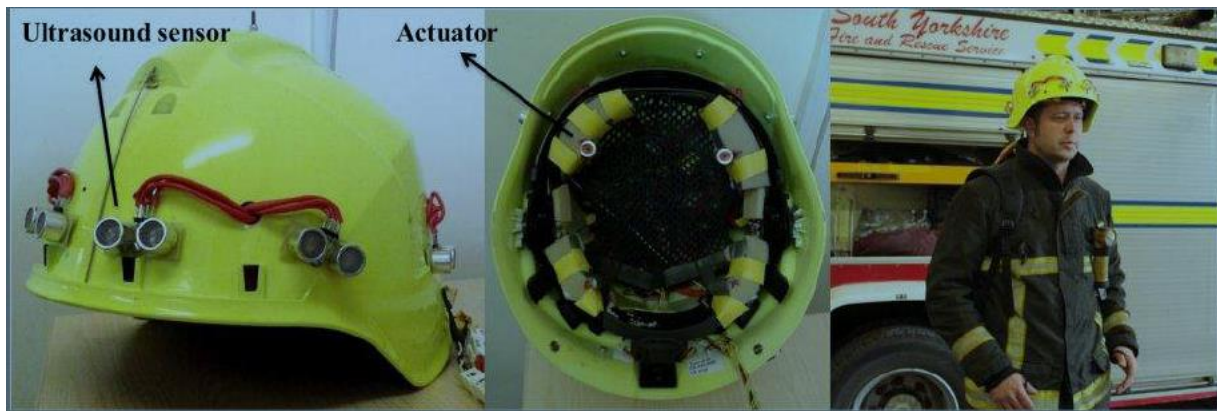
Vibrotactile firefighter helmet from Kerdegari et al. (2016).Kerdegari et al.'s helmet contained 12 ultrasonic range-finding sensors and six tactors.
